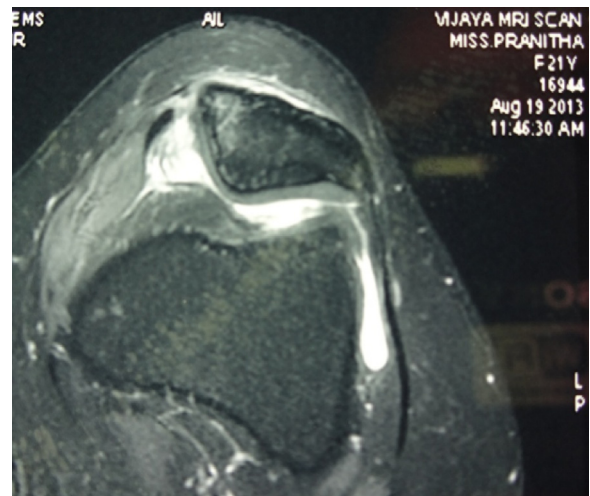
MRI image showing torn MPFL.
